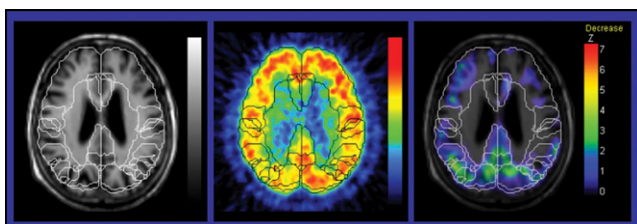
Left, MR; middle, ^{18}F -FDG PET; and right, Z-score automated analysis images in a 70-y-old woman with a Mini Mental Status Examination score of 27/30.
